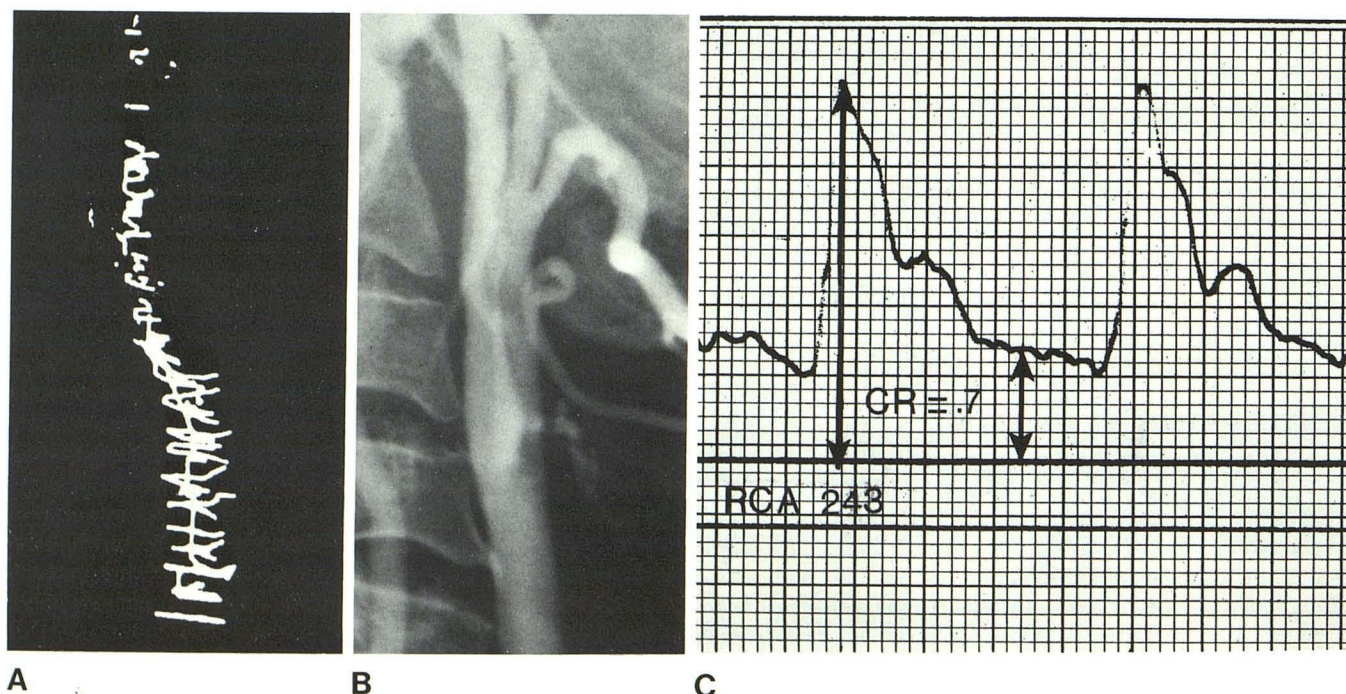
Superimposition of carotid bifurcation. A, Only one vessel was detected through Doppler examination of right bifurcation, resulting in false-positive diagnosis of internal carotid occlusion. Ipsilateral posterior orbital flow signals (not shown) were of normal direction but of lower amplitude than
